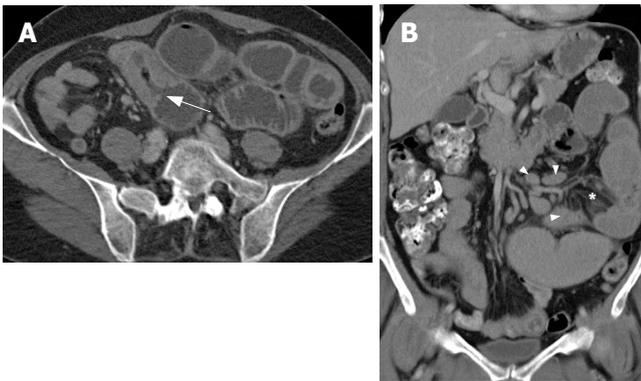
Axial CT image (A) demonstrates EATL (arrow) and prestenotic dilatation of jejunal loops. The coronal reformation (B) demonstrates dilated jejunum with infiltrated mesenteric fat (*) and multiple enlarged lymph nodes (arrowheads).
